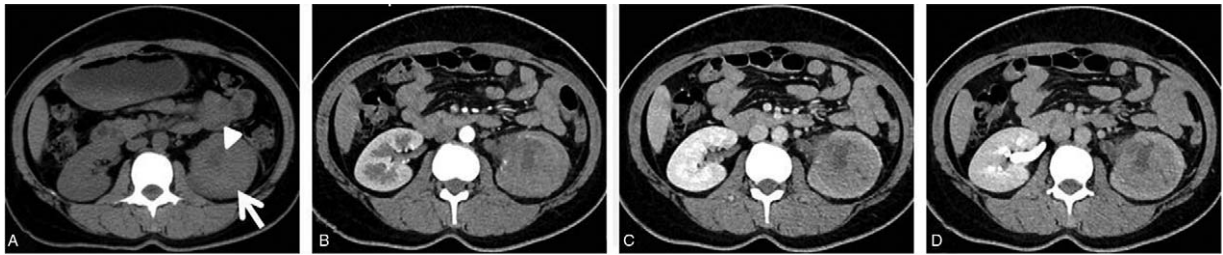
(A) Unenhanced CT scan shows a mass (white arrow) with necrosis (white triangle) in the left kidney. (B–D) On contrast-enhanced CT images, the tumor presents progressive and heterogeneous enhancement. CT=computed tomography.
